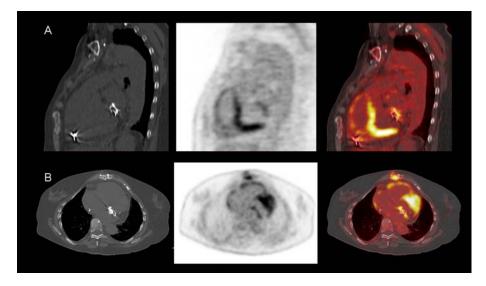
Sagital (A) and transverse (B) ¹⁸F-FDG PET/CT images show an infected prosthetic mitral valve. The culture was positive for *Coagulase-negative Staphylococcus*. Note that the high background myocardial uptake was not cause of misdiagnosis.
